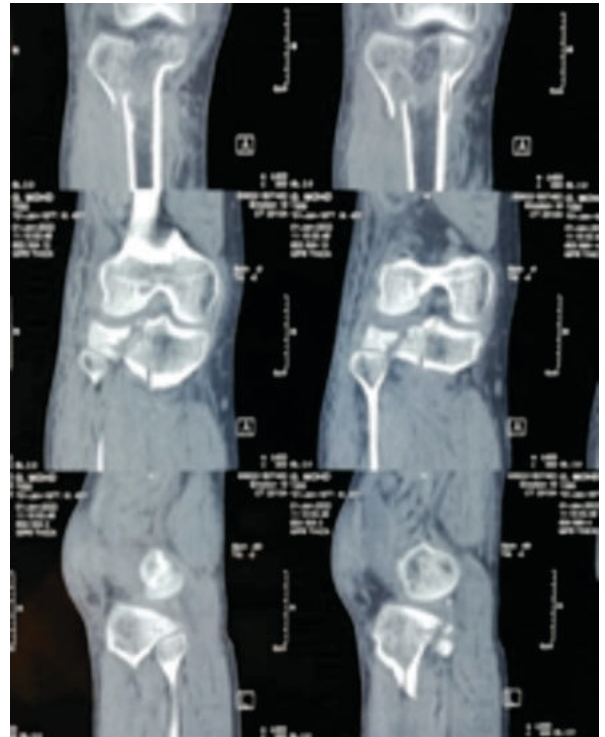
CT Coronal and Sagittal cuts of the same patient
